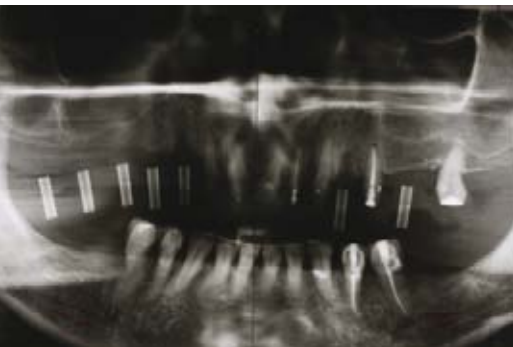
Panoramic radiograph with the maxilla drilling template inserted.
